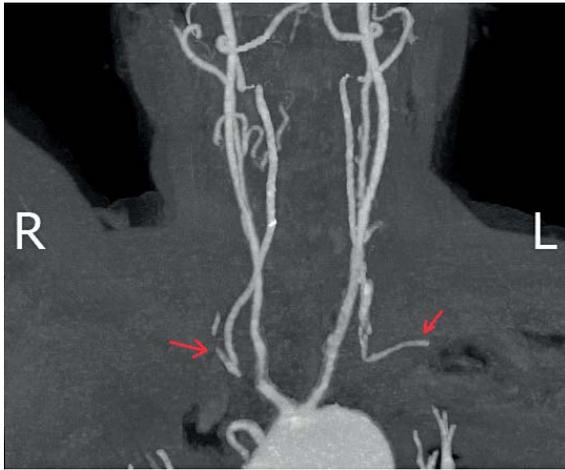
CT scan of aortic arch and its branches (frontal plane). Bilateral severe subclavian artery stenosis (red arrows)
